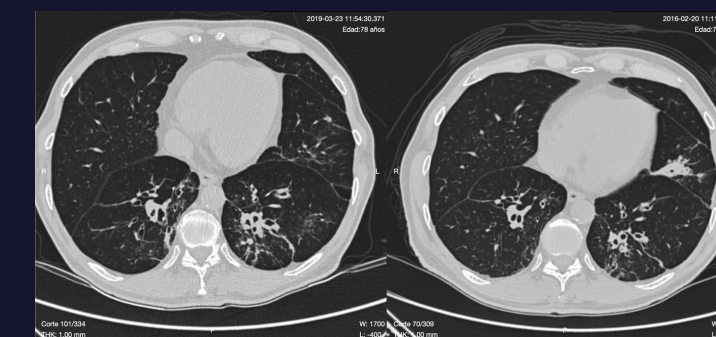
Comparative Chest CT after and before implementation of the low-dose protocol. There was a significant reduction in radiation dose (>60%) without compromising diagnostic image quality. A 78 Y.O smoker patient with a history of chronic bilateral basal bronchiectasis and recently diagnosed Non-small cell lung cancer (NSCLC). The CT acquired with the traditional protocol had a DLP of 598.3 mGy, equivalent to 8.3 mSv, and the low-dose protocol had a DLP of 222.3 mGy, equivalent to 3.1 mSv. A reduction of 62.84%.
